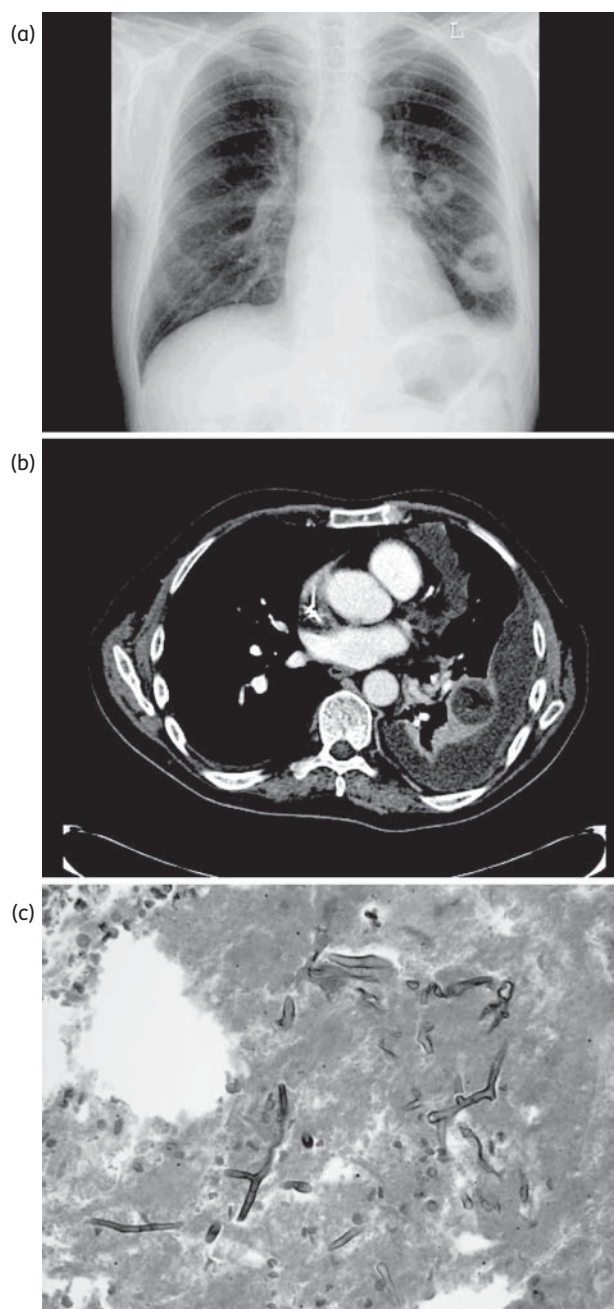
A chest X-ray taken 3 days before the initiation of treatment with ABLC showed two well-rounded, thick-walled cavities with air fluid levels in the left mid and lower lung fields (a). A chest CT scan revealed a round cavity-like lesion with fluid and an air pocket in the left lower lung (b). A left lower lung lobectomy was performed and two large areas of necrotizing granulomas with fungal hyphae consistent with *Mucor* were identified (c).
